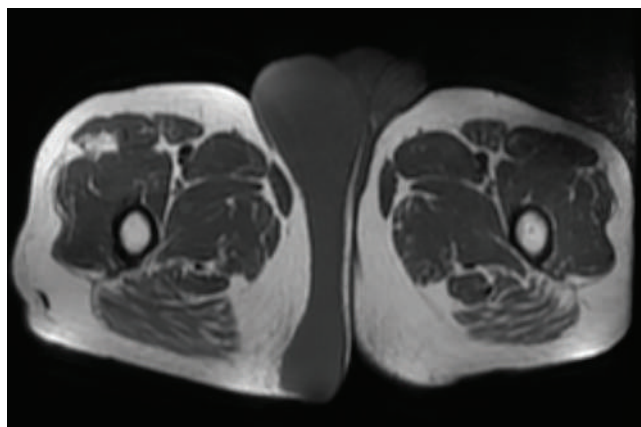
MRI image of the mass.
